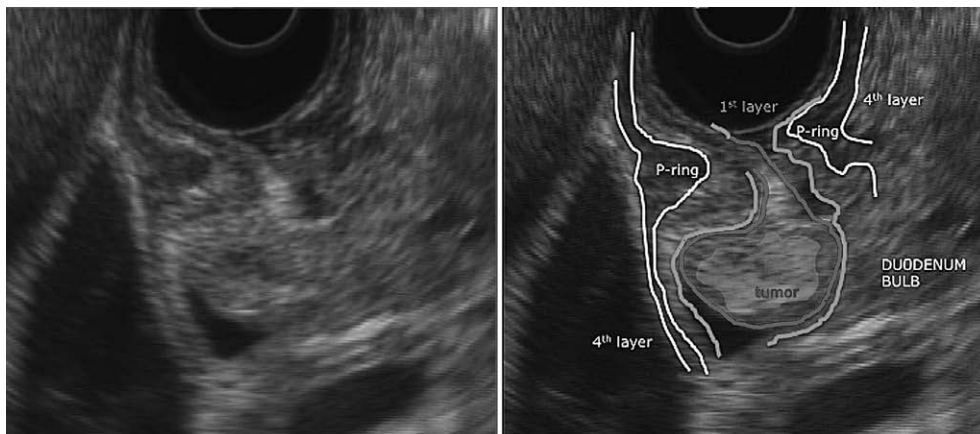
Endoscopic ultrasound imaging of the submucosal tumor (SMT). The SMT originated in the second layer, with the fourth layer below the tumor remaining intact. This tumor was therefore considered for removal by ESD with dissection along the fourth layer.
